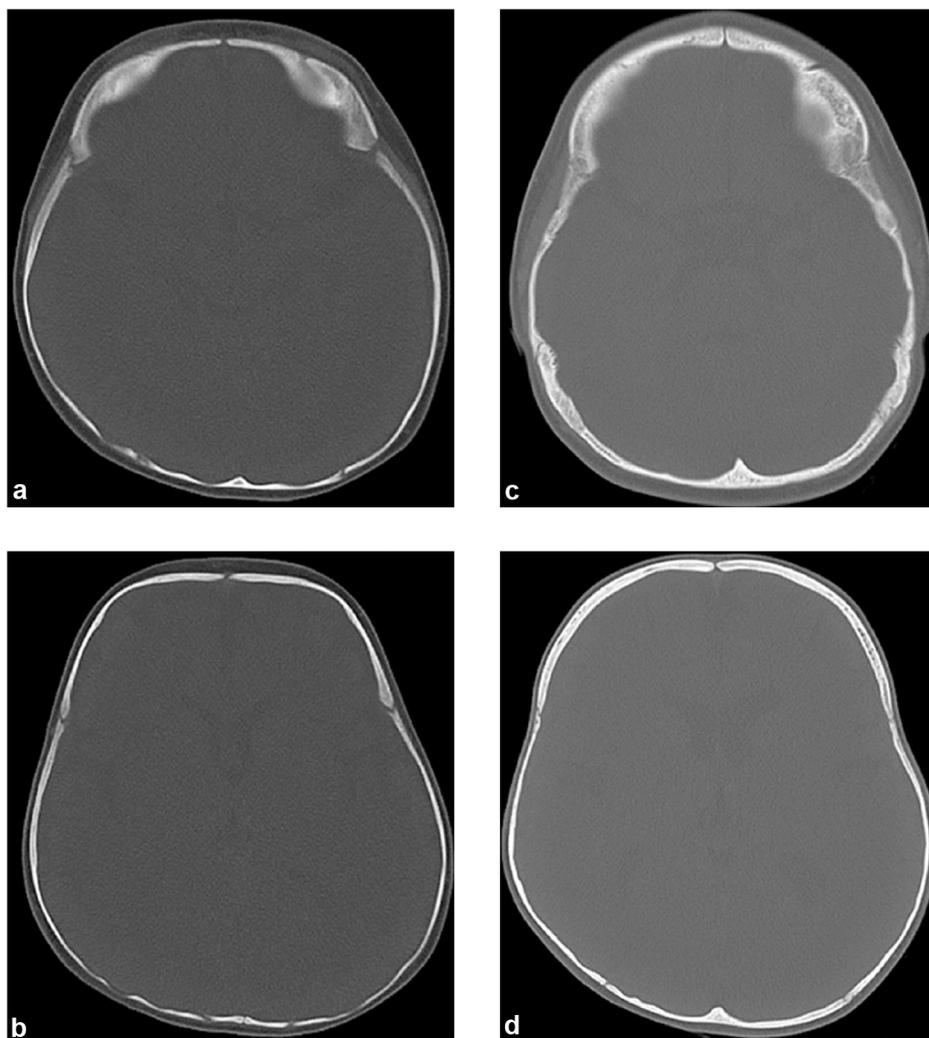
Cranial computed tomography (CT) image in the transverse plane using bone window at 4 months (275 mAs; 100 kV; slice thickness, 2.0 mm). a: Supraorbital slice; b: Supratentorial slice; c–d: Follow-up CT images at 18 months obtained with similar parameters than in a and b (352 mAs; 100 kV; slice thickness, 2.0 mm) show thickening and cranial sclerosis compared with the initial CT images at the same levels.
